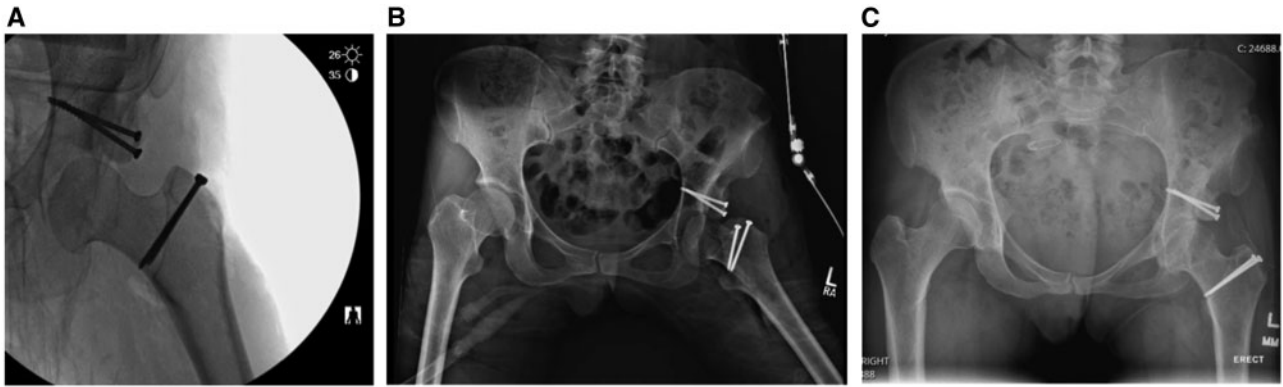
Post-operative X-rays. (A) Intra-operative left hip AP fluoroscopic view demonstrating adequate femoral head reduction. (B) Post-operative AP pelvis X-ray in hip abduction brace. (C) 8-Month post-operative AP pelvis X-ray.
